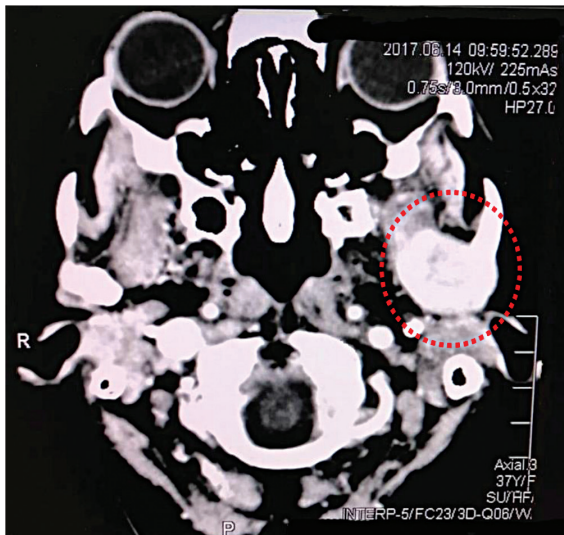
CT scan shows destructive bony lesion of left mandibular condyle with widening of the left temporo-mandibular space, filled with enhancing soft tissue component which extends to postero-lateral left lateral pterygoid muscle (inside red dotted circle)
